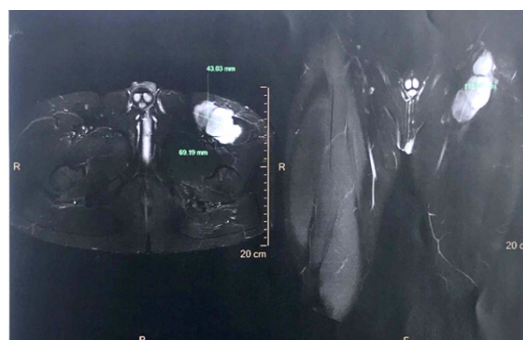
(A) Axial view of the femur MRI evaluation two years after first surgery & (B) Coronal view showed suggestive recidive sarcoma
